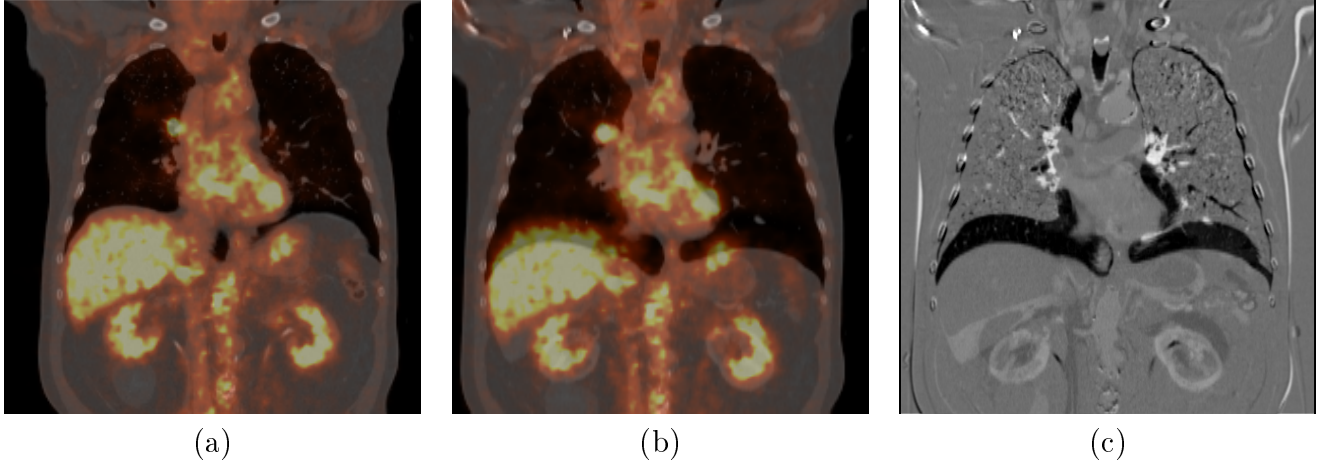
(a) Fused PET/ AC-CT image (b) Fused PET/Diagnostic CT (contrast-enhanced) image without registration (c) Difference image between AC-CT and Diagnostic CT.
